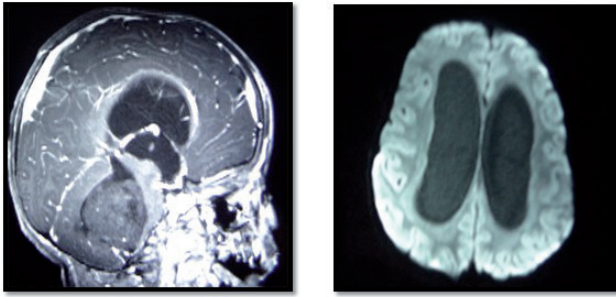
Head and medullar MRI: (a- Axial section, b- Sagittal section)
